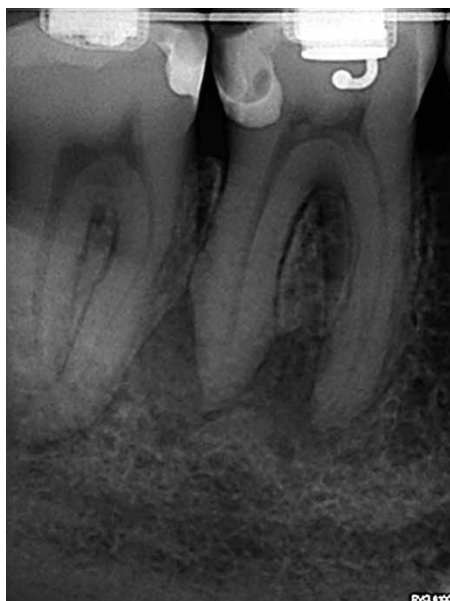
Case 1 — pre-op radiograph
